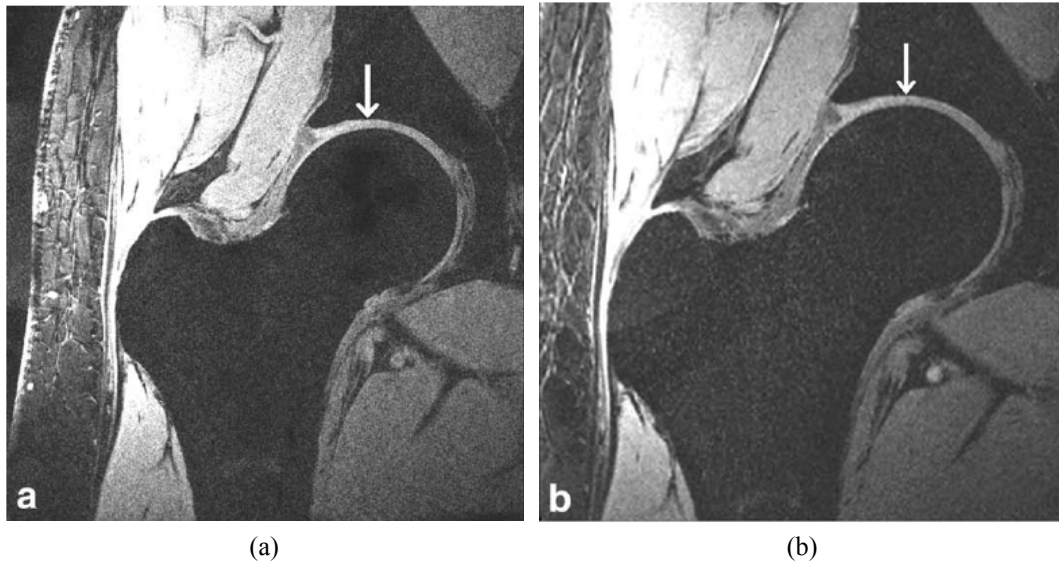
High-resolution MR imaging of hip joint cartilage at 7 T: (a) 3D water-excitation FLASH and (b) 3D frequency-selective fat suppressed VIBE sequences at a resolution of  $0.23 \times 0.23 \times 1.5 \text{ mm}^3$  (Used without permission from (Chang et al. 2014)).
